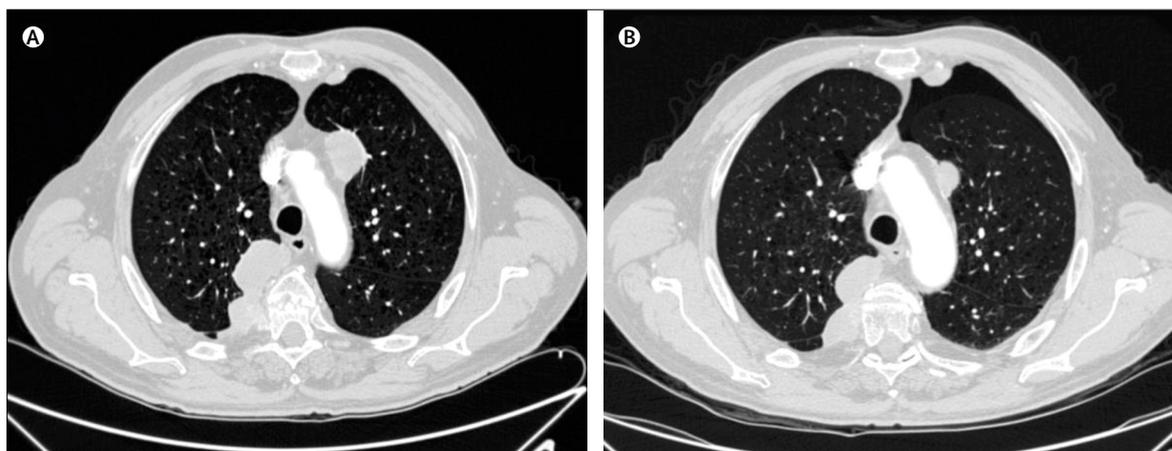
Thoracic CT scan before (A) and after (B) the development of pneumothorax
